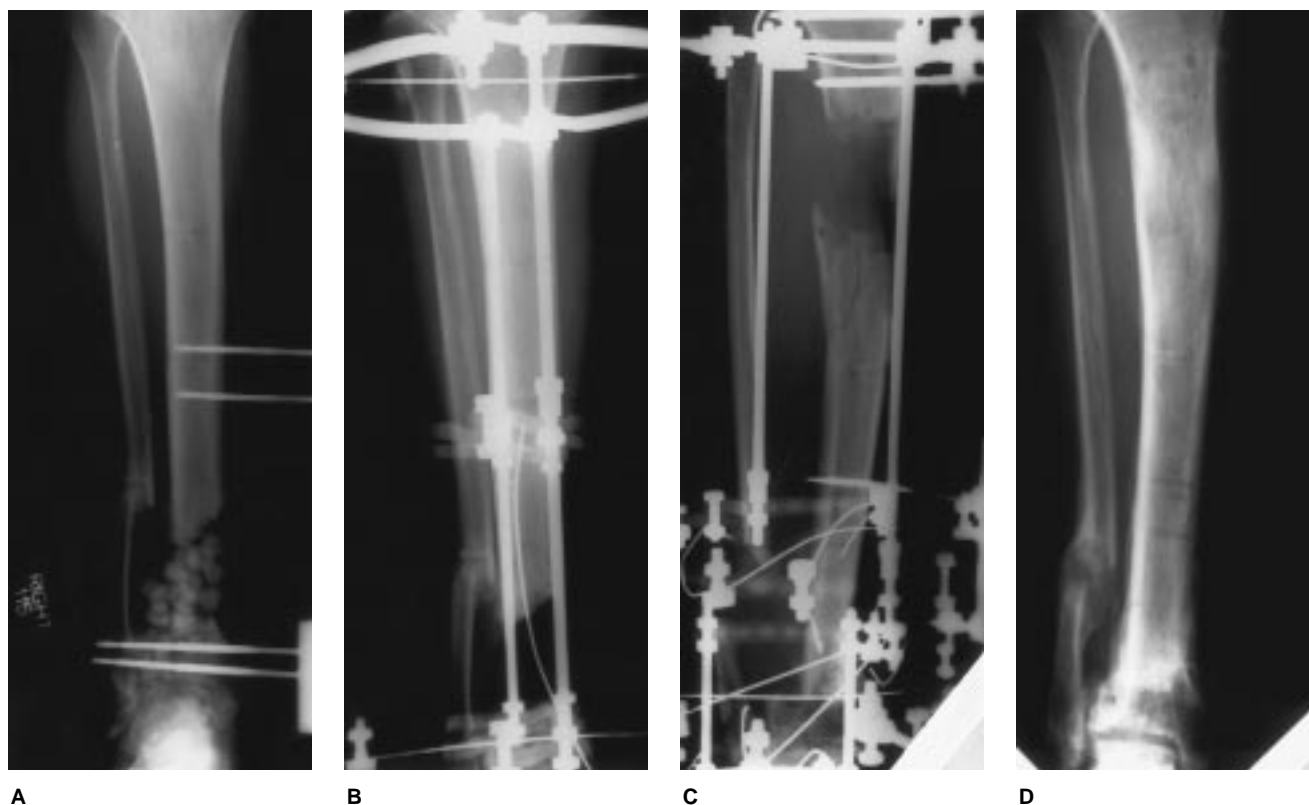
Radiographs of an adult diabetic patient with segmental loss of bone secondary to osteomyelitis as a result of infection after open reduction and internal fixation. A, Segmental defect was packed with antibiotic-impregnated methylmethacrylate beads. B, External fixator constructed to perform bone transport. Intraoperative film shows reference wires and intraosseous guide wire in place. C, Appearance after docking distally. Proximal regenerate is beginning to be visible. D, Film obtained after frame removal shows successful healing of the docking site and regenerate formation. Length of treatment until device removal was 7 months; bone grafting was not necessary.
